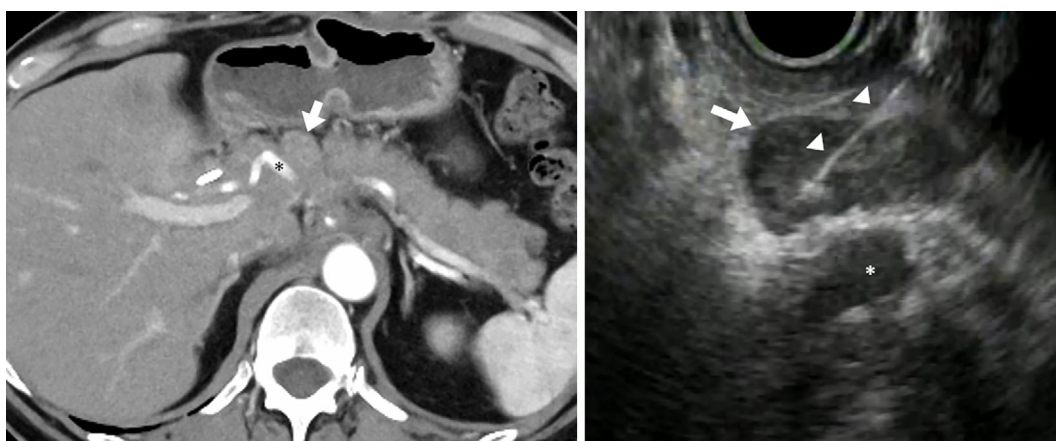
CE-CT and EUS images (January, 20XX+1). EUS-FNA (arrowhead) was performed for the #8a lymph nodes (arrow) (*common hepatic artery).
